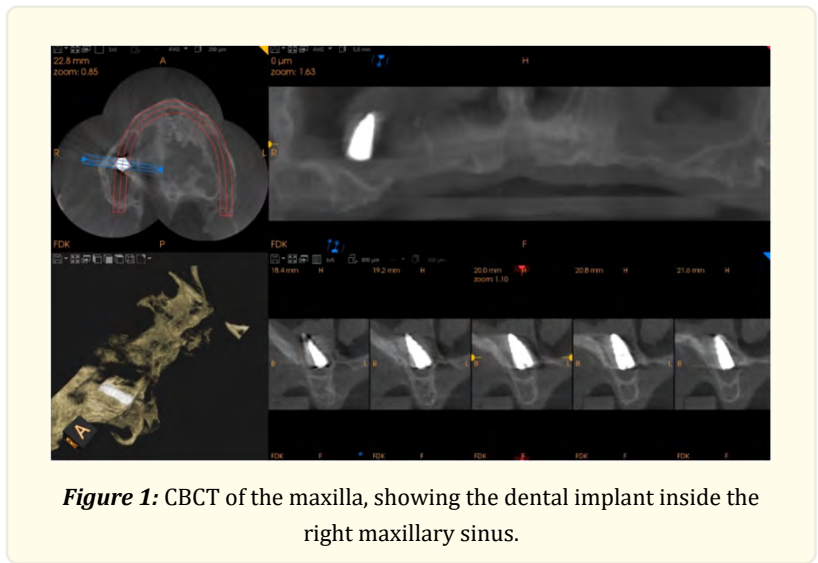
CBCT of the maxilla, showing the dental implant inside the right maxillary sinus.
